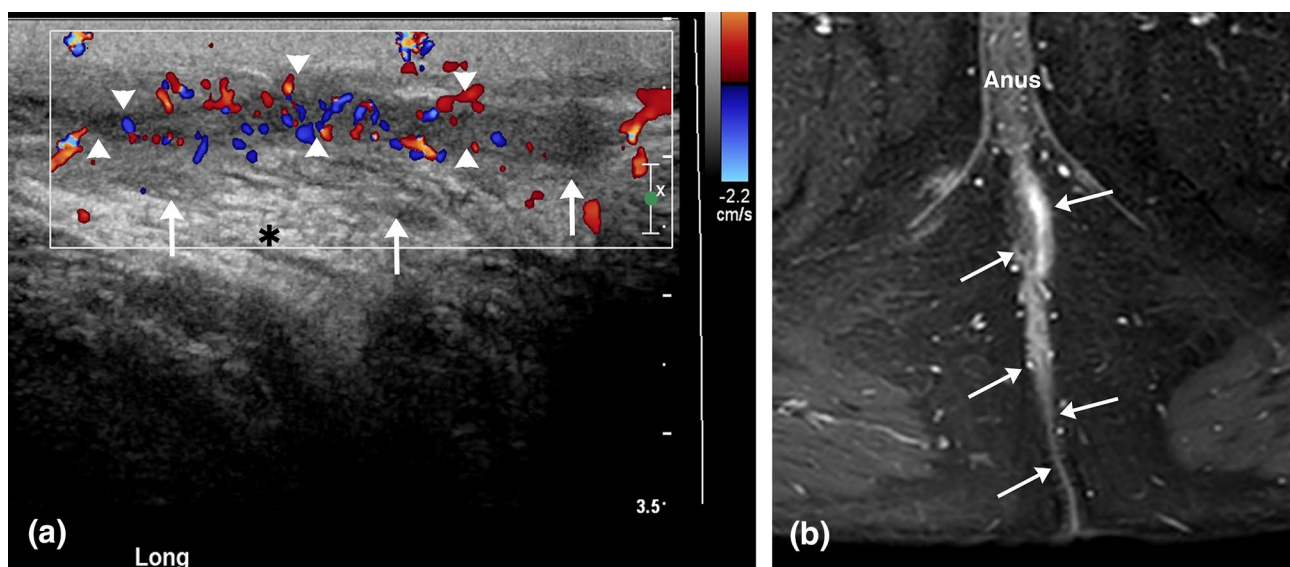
Perianal fistula in a 43-year-old male with tenderness and erythema of the perineum. a Longitudinal color Doppler image of the left perineum obtained via perineal approach demonstrates a hypoechoic complex tubular structure (arrow heads) representing a fistula track. The track is extending from the subcutaneous tissues of the perineum to the anal canal (not shown). Note marked stranding
